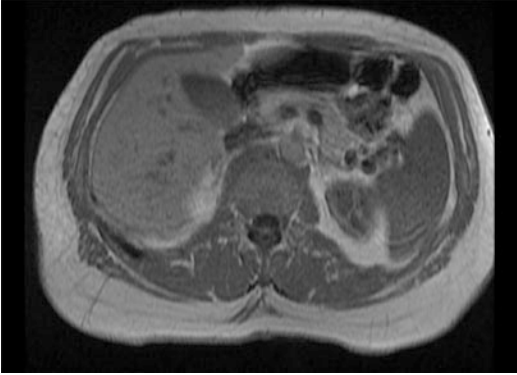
T2-weighted abdominal magnetic resonance imaging
